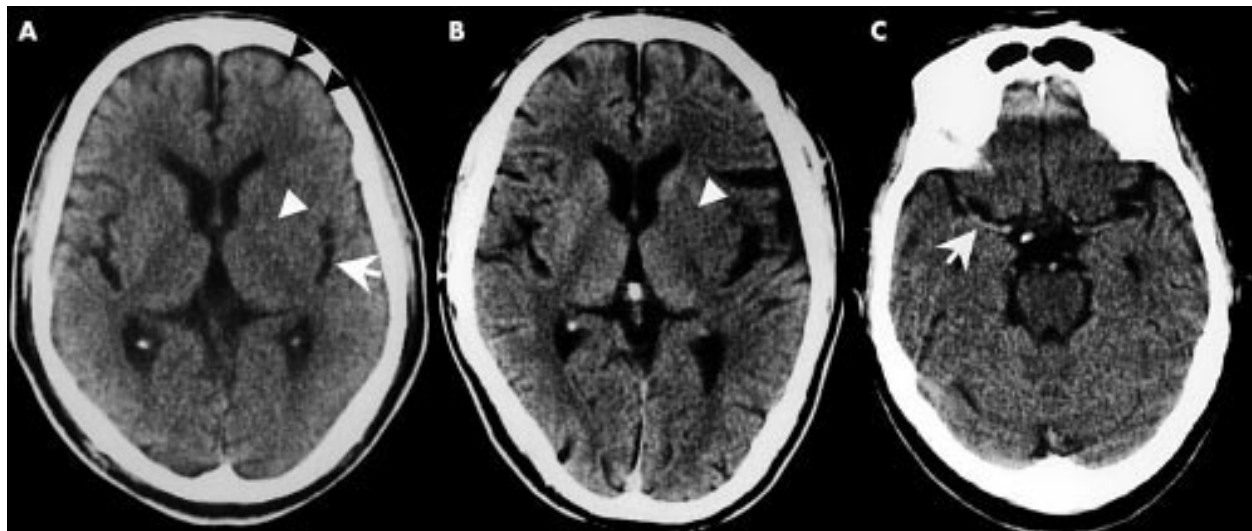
(A) Non-contrast brain computed tomography (CT) of a patient with embolic occlusion of the left internal carotid artery 2.5 hours after onset, showing loss of the insular ribbon (LIR, white arrow), attenuation of the lentiform nucleus (ALN, white arrowhead), hemispherical sulcus effacement (HSE, black arrowheads). (B) Non-contrast brain CT of a patient with embolic occlusion of the sphenoidal portion (M1) of left middle cerebral artery three hours after onset, showing ALN (white arrowhead). (C) Non-contrast brain CT of a patient with embolic occlusion of right M1 1.5 hours after onset, showing the hyperdense middle cerebral artery sign (HMCAS, white arrow).
